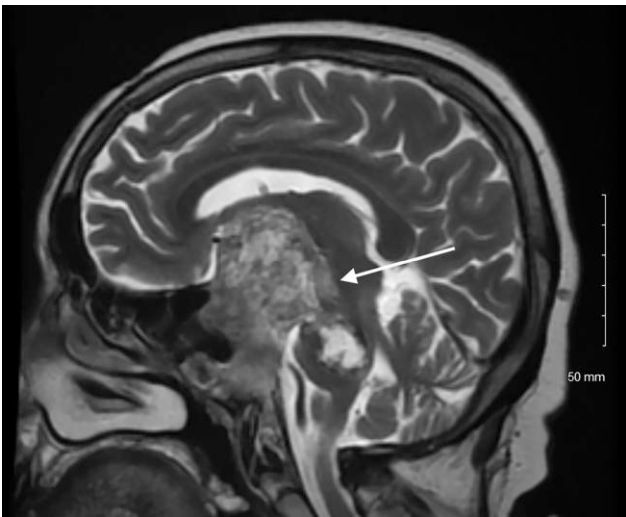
Magnetic resonance imaging of the brain (T2-weighted sagittal view) with increased size of the ventricular system. There is no clear differentiation between the pituitary gland and the skull base mass.
